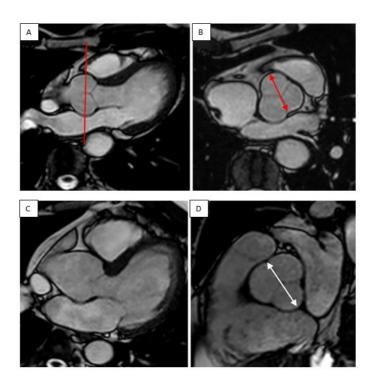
Normal Aorta versus Aortic Dilation in Mid-life Males.* (A & B) Aortic root MRI of 44-year-old male with normal aortic dimensions during end diastole; (C & D) Magnetic Resonance Imaging (MRI) of mild dilated aortic root in 37-year-old male during end diastole. Adapted from the work of Hoey and colleagues (498).*
